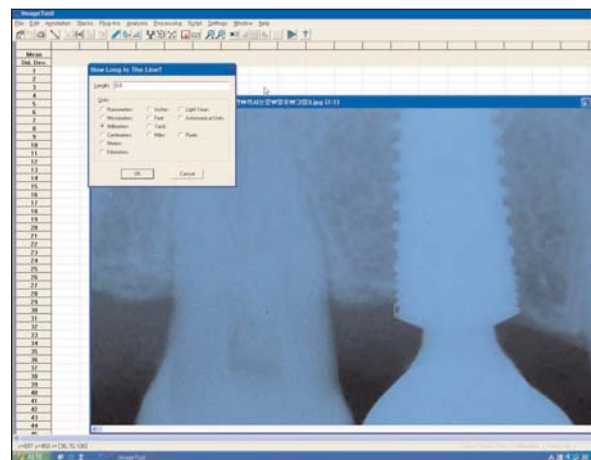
Digital processing of a radiographic image using UTHSCSA Image Tool software.
